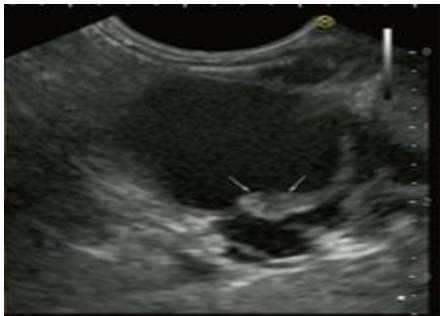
Endoscopic ultrasound image of an IPMN
